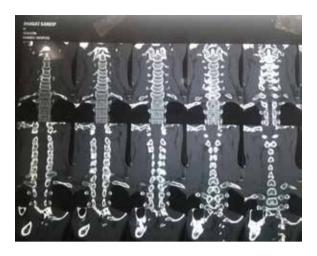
CT Scan showing Bilateral Cervical rib
